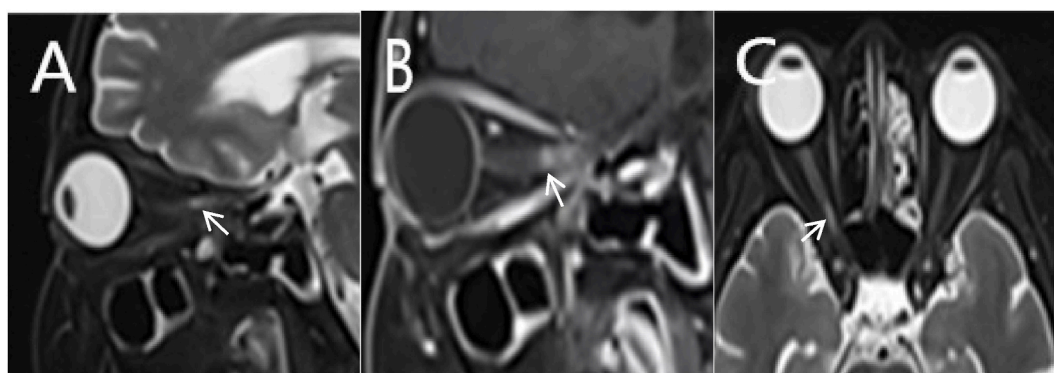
Optic nerve MRI following the second recurrence of NMOSD. Sagittal T2-weighted imaging (A) showed hyperintensity of the right optic nerve; sagittal post-Gd T1-weighted imaging (B) showed hyperintensity of the right optic nerve; axial T2-weighted imaging (C) showed hyperintensity of the right optic nerve.
